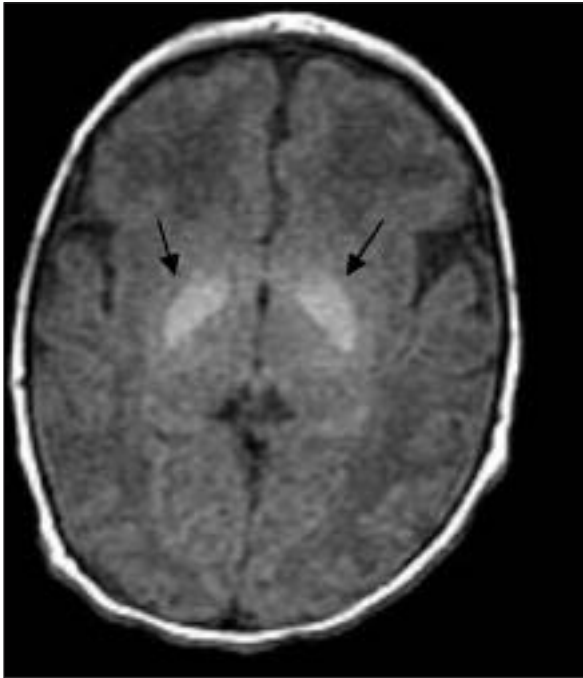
Axial T1-weighted MRI shows symmetric, hyperintense GP involvement.
